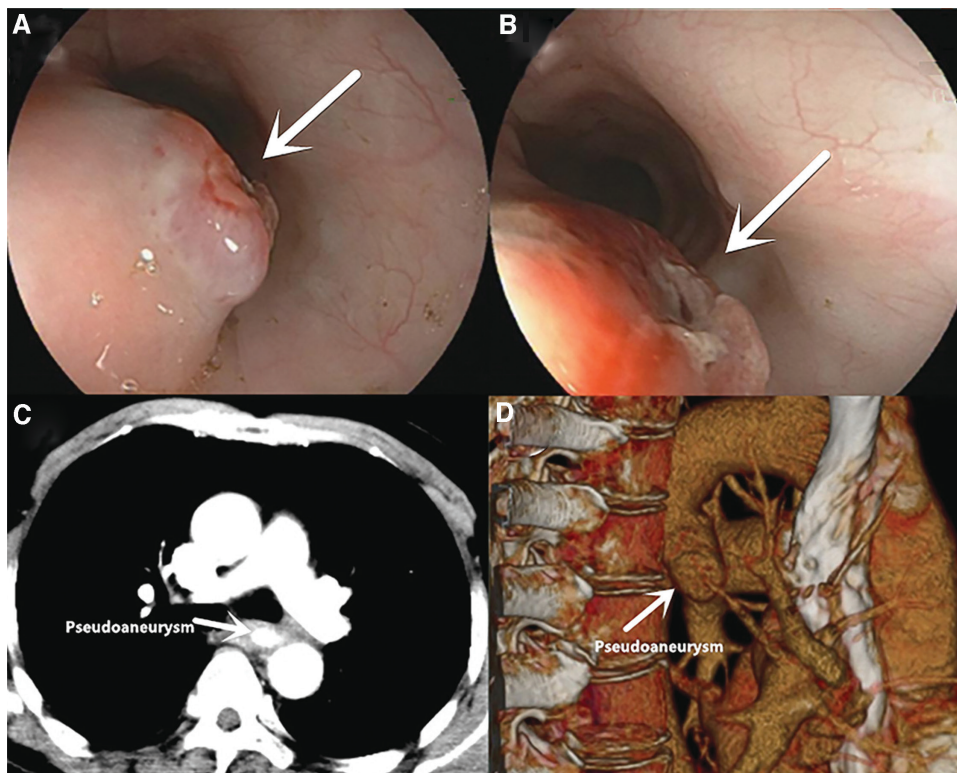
The presurgical examination. (A, B) Esophagogastroduodenoscopy shows an esophageal submucosal tumor-like protrusion with an ulcerative lesion 26 cm below the incisors. (C) Transverse and (D) three-dimensional volume-rendered computed tomography angiography shows the pseudoaneurysm of the descending aortic arch, swelling of the wall of the descending aorta, and blurred surrounding space.
